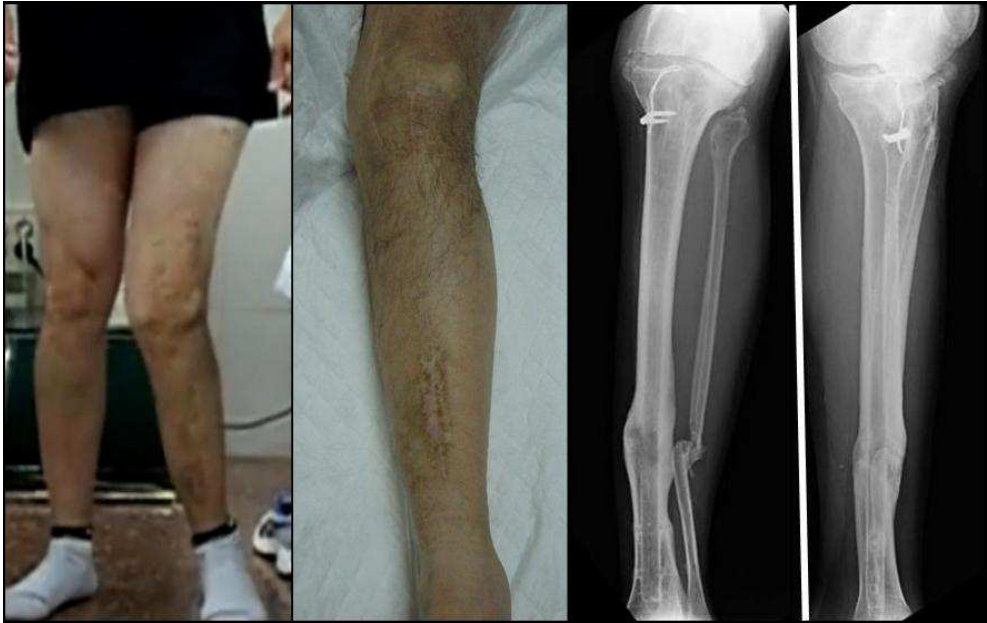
Initial clinical and radiographs examination
